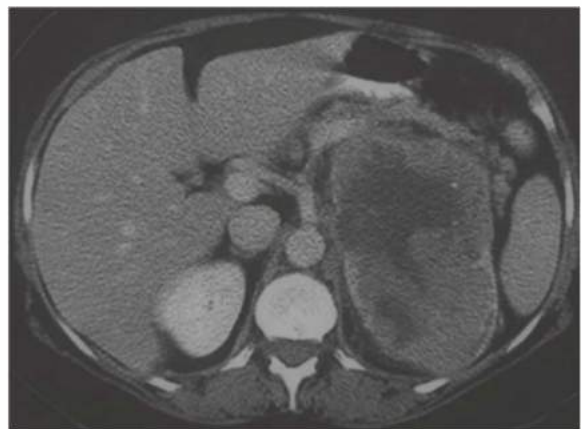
• CT scan of left adrenocortical carcinoma.
